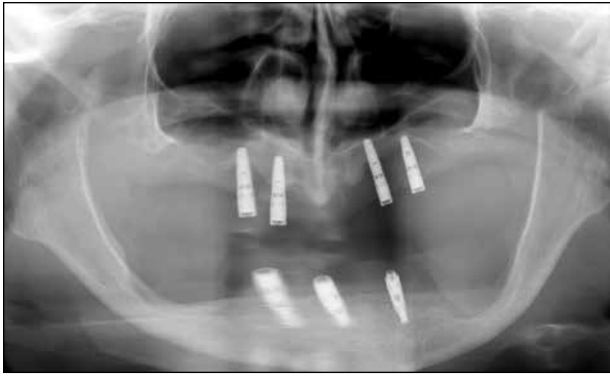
The initial panoramic radiograph reveals a maxillary atrophic condition derived from severe and untreated peri-implantitis. It is a radiologic indication for NZP rehabilitation.
